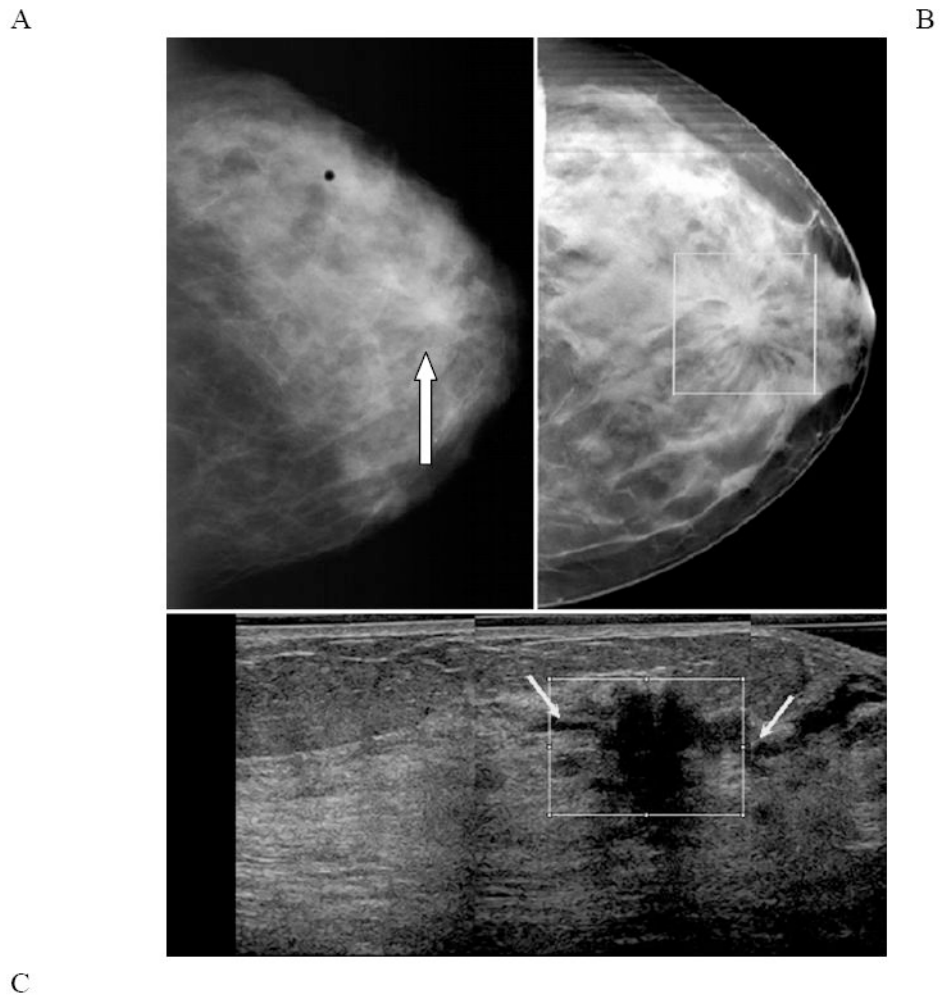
(A-C)– Images from a combined DBT and ultrasound system. The DBT and US image were obtained automatically during a single compression. Conventional film screen (CC) mammogram (A), DBT 1 mm thick image (B) and the corresponding automated ultrasound image (C) of a patient with invasive cancer. The cancer is subtle on conventional mammogram (arrow) and apparent on the DBT (within box) and very apparent on ultrasound image (within box, arrows).
